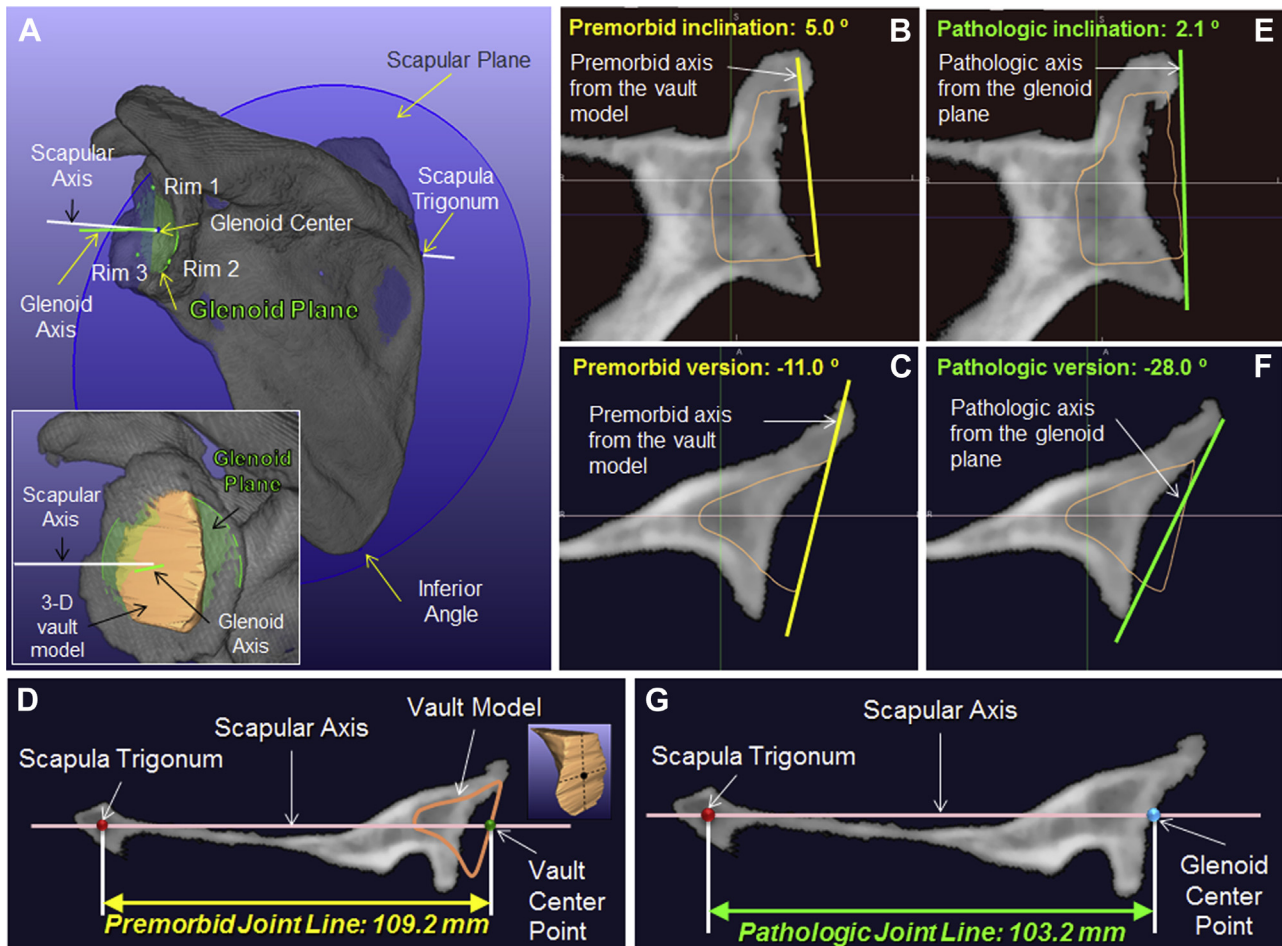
(A) The scapular plane is defined using the glenoid center point, inferior angle of the scapula, and scapula trigonum. The glenoid plane is defined using 3 representative points placed on the surface of the glenoid fossa. Pathologic glenoid version and inclination are then measured 3-dimensionally (3D) from the scapular and glenoid planes. The medial-lateral joint line position is measured as the distance between the glenoid center point and the scapular trigonum. The glenoid vault model (*inset*) is virtually placed into the glenoid of each preoperative computed tomography scan as a tool to define pre-morbid glenoid anatomy. Pre-morbid glenoid version and inclination are measured 3-dimensionally from the scapular plane and the plane of the glenoid vault surface. The pre-morbid medial-lateral joint line position is measured as the distance between the glenoid vault center point and the scapula trigonum. (B-G) Representative 2-dimensional orthogonal views relative to the scapular plane are used to confirm vault model position and demonstrate pre-morbid (B-D) and pathologic (E-G) version, inclination, and medial-lateral joint line position relative to each other.
